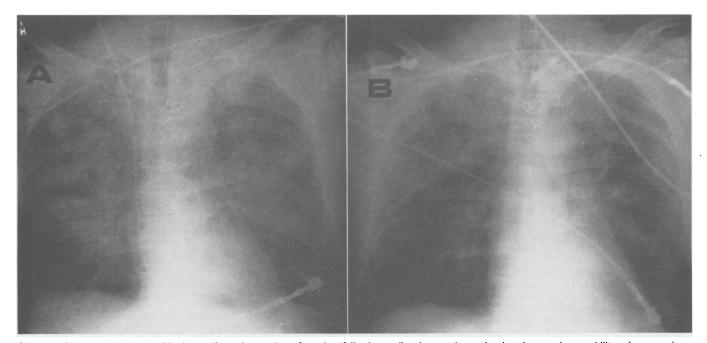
A, Anteroposterior portable chest radiograph was taken of a patient following cardiopulmonary bypass in whom increased permeability pulmonary edema developed. The pulmonary arterial wedge pressure was 9 mm of mercury. The initial pulmonary edema fluid:plasma protein ratio was 0.85 at the time of this chest radiograph. B, Four hours later, a repeat chest radiograph was taken when the alveolar-arterial oxygen difference had decreased and a second pulmonary edema fluid: plasma protein concentration ratio had increased to 1.2. Note that the extent of pulmonary edema is significantly less on this second chest radiograph.
